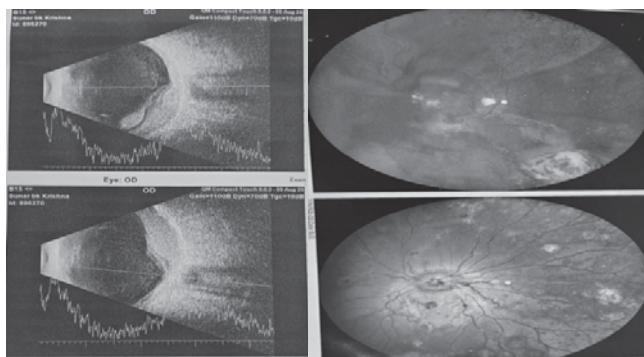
Ocular imaging with B-scan ultrasonography and Scanning Laser Ophthalmoscopy confirmed the presence of dense vitreous hemorrhage with partial superior retinal detachment.
